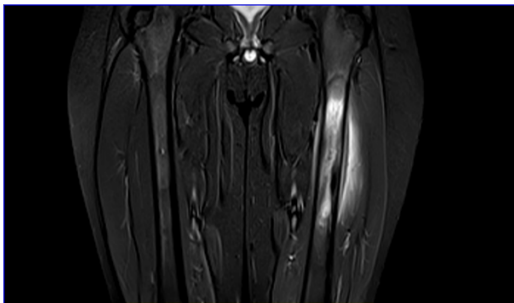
STIR coronal MRI of a female child shows Altered signal in the noted in the left femur with adjacent soft tissue component-Left Ewing's sarcoma
